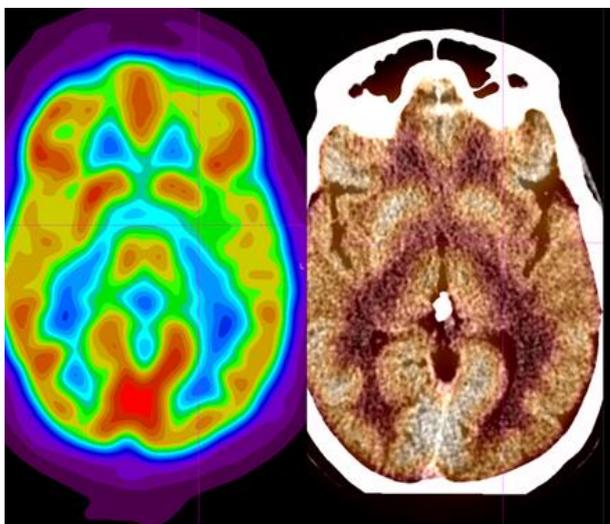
Hashimoto's encephalopathy. Positron emission tomographic (PET) imaging from the vertex to foramen magnum following injection of 10 mCi ¹⁸Fluoro-D-glucose (left image) shows severely reduced metabolic activity in the posterior half of the left putamen on standard PET imaging, and with fusion to gadolinium-enhanced magnetic resonance imaging (MRI) (right image).
